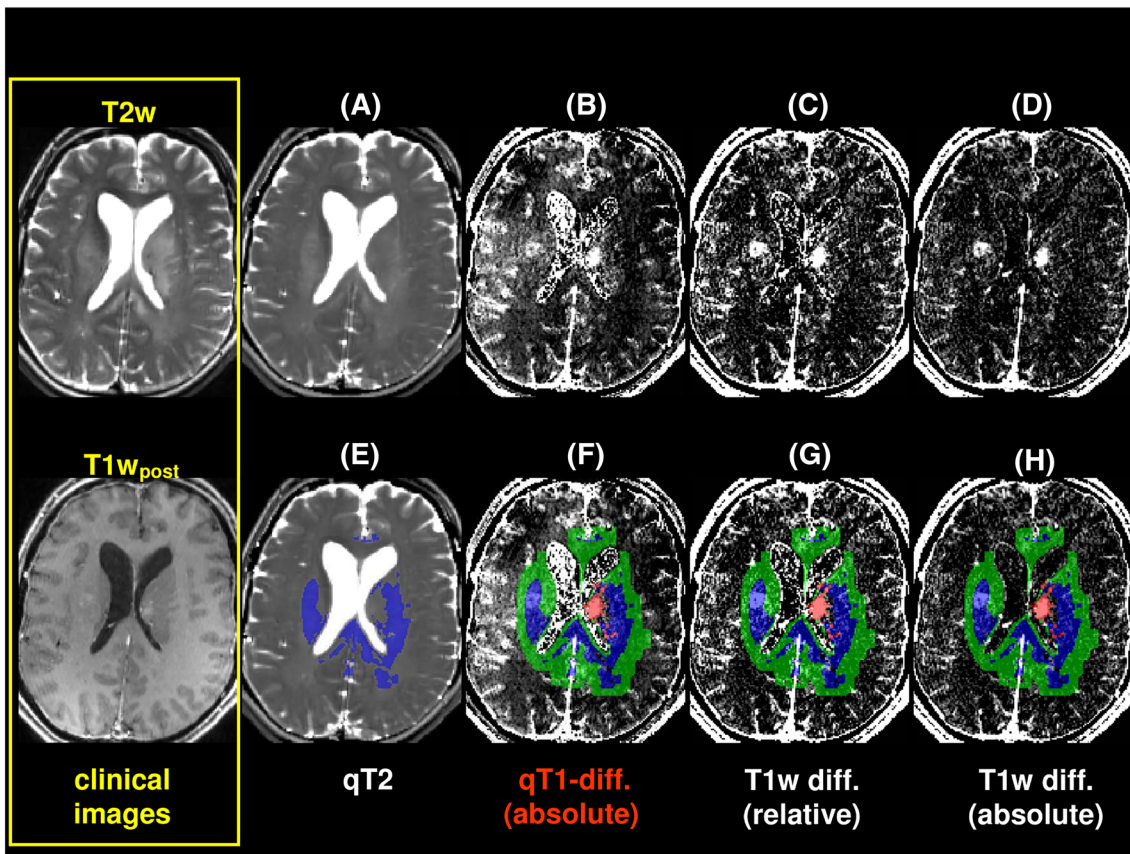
Data of a patient with a glioblastoma adjacent to the right lateral ventricle and surrounded by edema. The yellow frame (left) shows a conventional T2-weighted (T2w) image (top) and the T1w image post contrast agent (T1w_{post}) (bottom) for orientation. Further, the top and bottom rows show from left to right: quantitative T2 (qT2) map (A, E), absolute qT1-difference map (B, F) and relative (C, G) and absolute (D, H) differences of T1w images. In the bottom row, the volume of interest (VOI) masks are superimposed: enhancing tumor (red), edema (blue) and 5 mm zone (green). The qT1-difference map (B, F) shows enhancement beyond the left-sided edema region (blue mask) and 5 mm zone (green mask), which is not visible in the T1w difference images (C, D, G, H)
